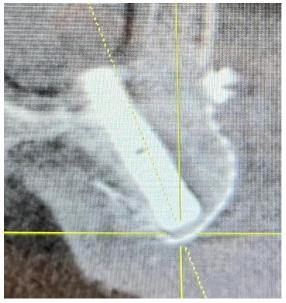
CBCT check bicortical at 6 months
